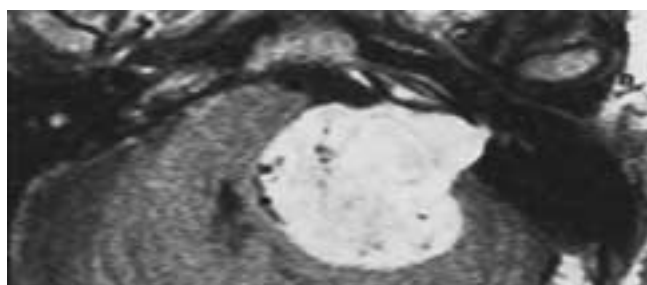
Large acoustic schwannoma, T1-weighted postgadolinium image. Note the serpentine flow voids of the vessels in this relatively vascular tumor and the displaced tributaries of the petrosal and capsular veins on the surface of the tumor.
